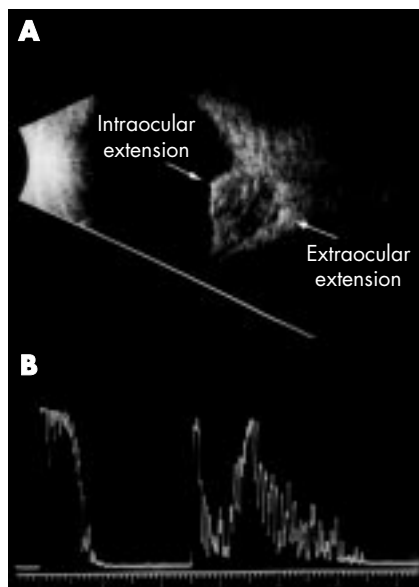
(A) B-scan ultrasonography demonstrates extraocular extension of the tumour and exhibits the choroidal excavation, acoustic quiet zone, and orbital shadowing characteristic of a uveal melanoma. Arrows surround areas of tumour extension. (B) A-scan ultrasonography shows spontaneous pulsation, low to medium internal reflectivity, and a sharp posterior spike. The measured intraocular tumour thickness was 3.0 mm with 7.7 mm of extraocular extension.
